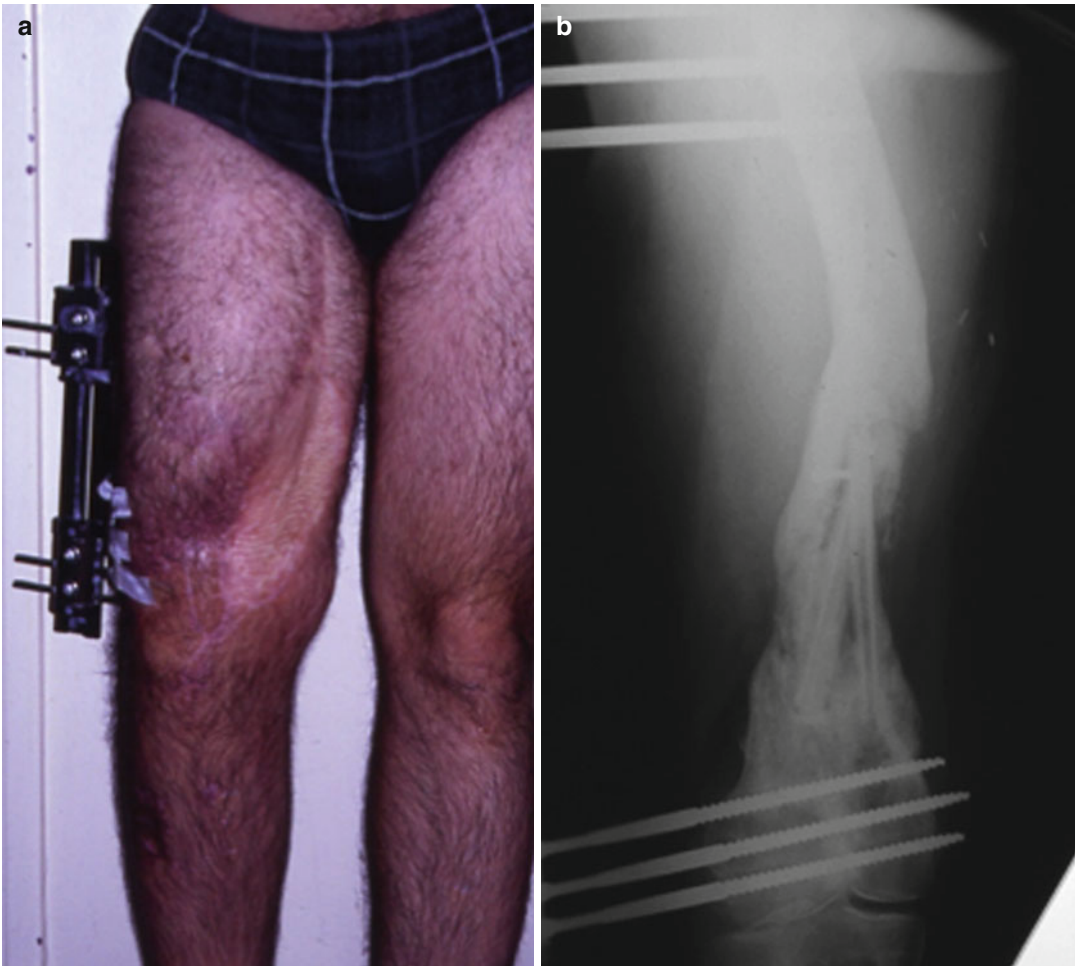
(a) Clinical photograph of femoral defect treated by external fixation and free latissimus dorsi flap on the anterior thigh. (b) X-rays with a double-barrelled free fibular transfer for bone reconstruction
